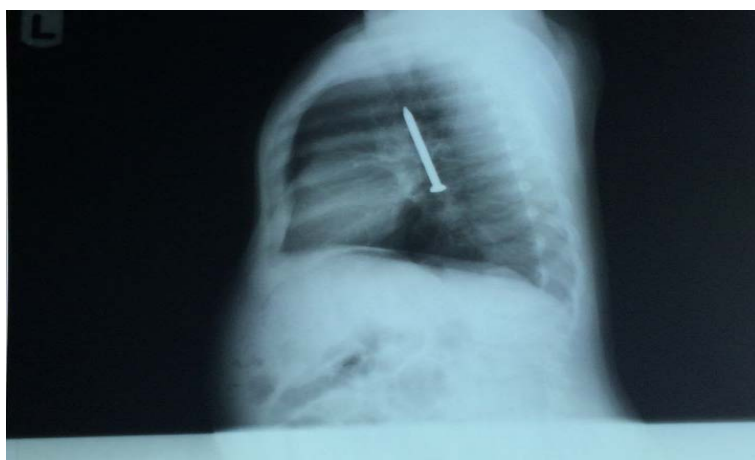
Plain chest X-ray of the patient lateral view.
